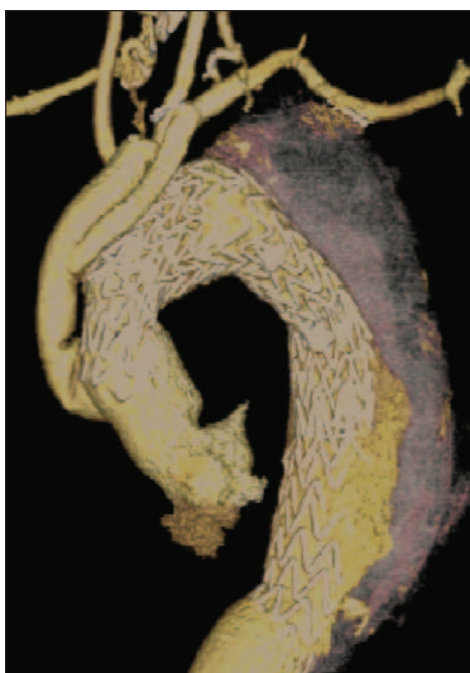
A 64-slice computed tomography reconstruction on a Hybrid Type II repair of a chronic aortic arch dissection extending into the descending thoracic aorta with revascularization of the great vessels.
